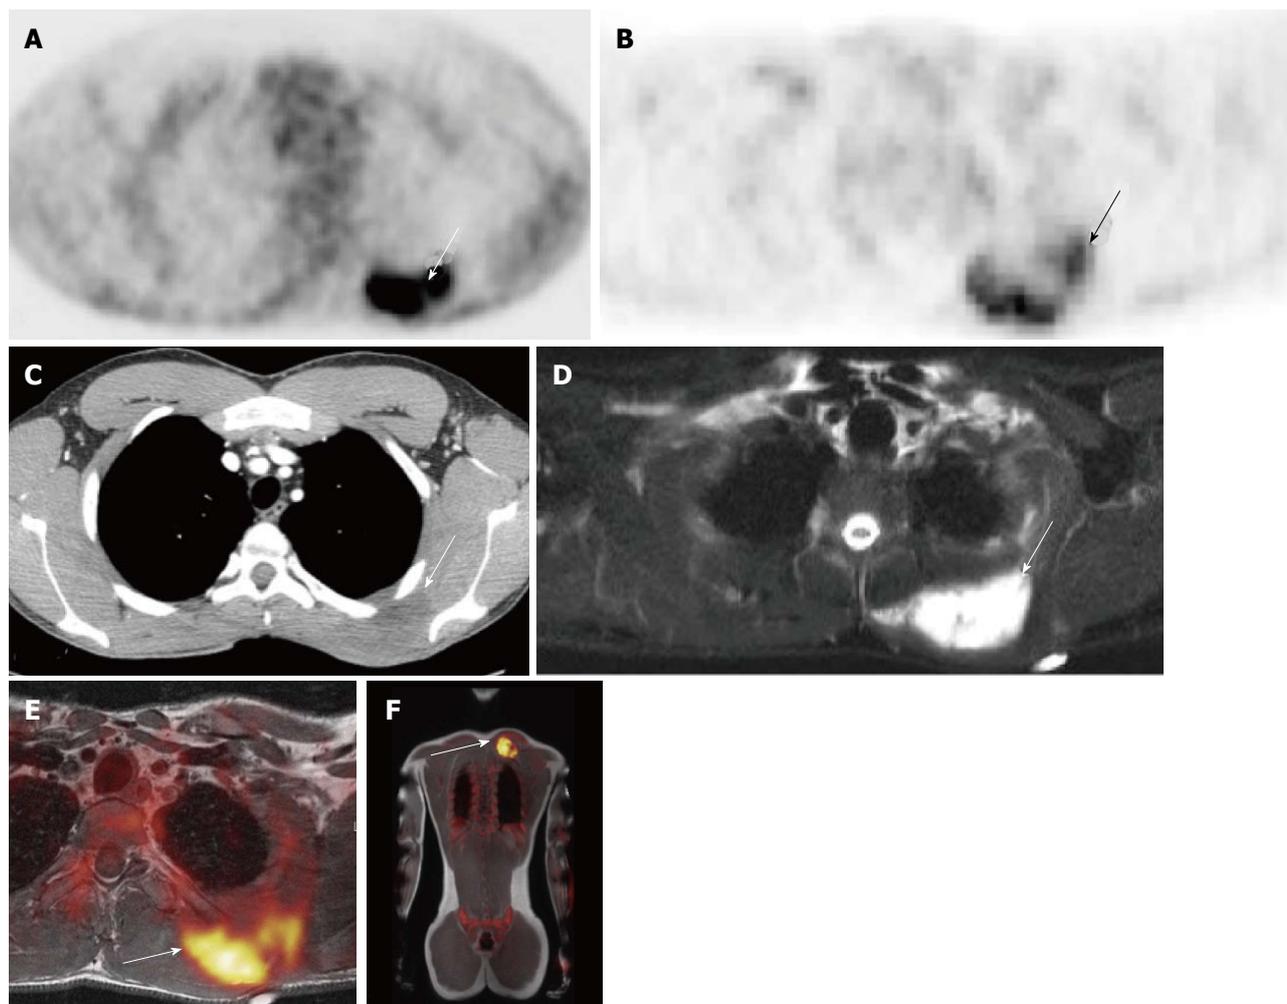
19-year-old male with undifferentiated malignant small round cell sarcoma. Axial image from the PET-CT examination (A) shows intense uptake in mass in the left upper back (white arrow); axial image from the PET-MRI examination (B) shows similar FDG uptake in this region (white arrow); axial CT image from the PET-CT (C) shows a slightly hypodense mass in this region (white arrow). This mass is much better seen on the axial T2 fat suppressed image from the PET-MRI (D) (white arrow). Fused PET-MRI images [T1-weighted axial (E) and whole body coronal (F) MR sequences] again show intense FDG uptake associated with the mass in the left upper back (white arrows). PET-MRI: Positron emission tomography-magnetic resonance imaging; CT: Computed tomography; FDG: Fluorodeoxyglucose.
